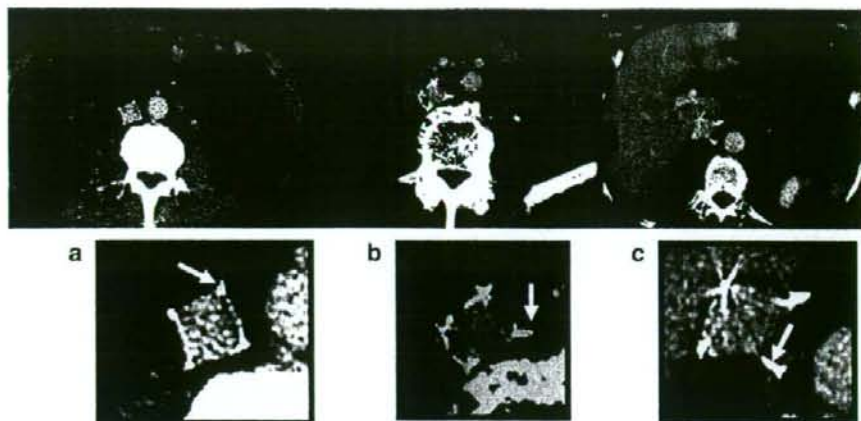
Extent of penetration of filter struts in 41 patients implanted with Günther Tulip Filter as a permanent filter who underwent enhanced computed tomography. (a) Penetration of the inferior vena cava (IVC) wall less than 3 mm ( $n=18$ ; 43.9%). (b) Penetration of the IVC wall from 3 mm to 6 mm ( $n=20$ ; 48.8%). (c) Penetration of the IVC wall more than 6 mm ( $n=3$ ; 7.3%).
